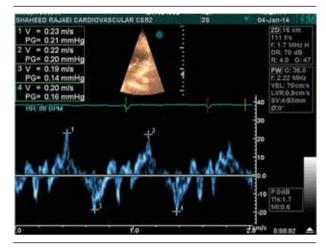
Prominent S wave in the Tissue Doppler Imaging of the Patients With Mitral Valve Prolapse
